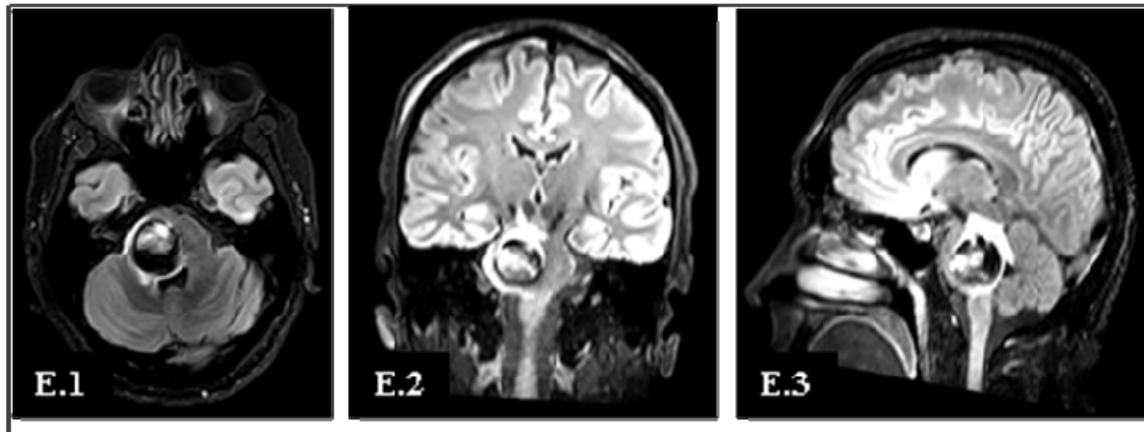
Post-operative MRI 3 weeks later, rebleeding.
